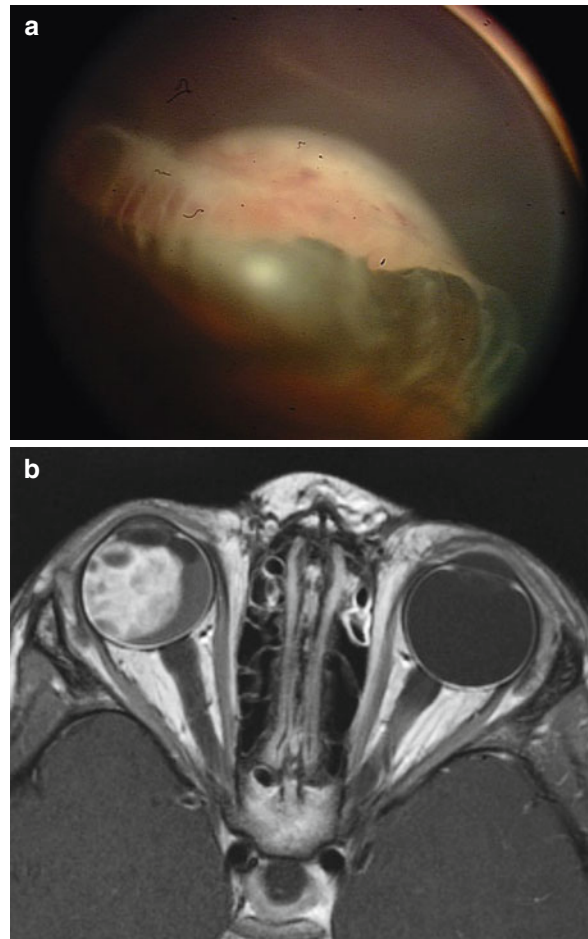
(a) Medulloepithelioma-Variably pigmented ciliary body mass. (b) MRI highlights characteristic intralésional cysts.
